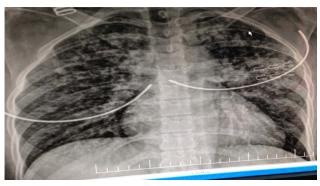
Chest X-ray demonstrates bilateral infiltrations in both lungs.
